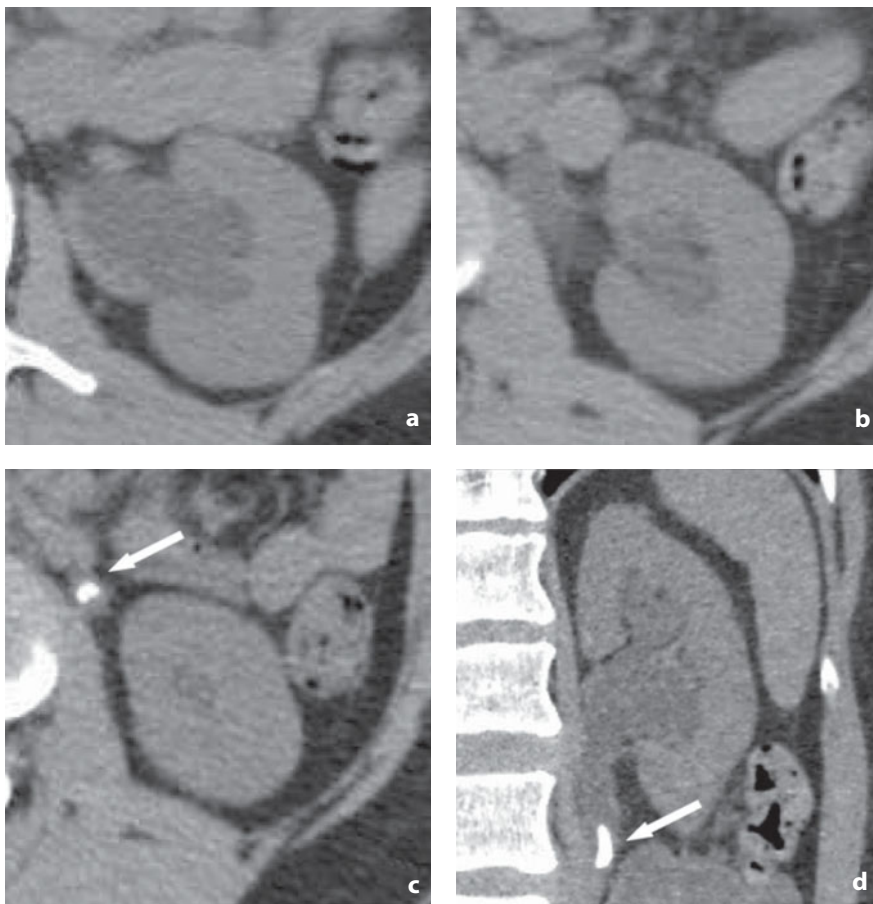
Nonenhanced CT. Ureteric stone (patient with left renal colic). Dilatation of the calices, pelvis ([a](#)), ureter with periureteric fat stranding ([b](#)) and stone (*arrow*) in the lumbar segment surrounded by ureteric wall edema (*rim sign*, [c](#)). The coronal reconstruction precisely shows the maximum dimensions and the site of the stone (*arrow*) ([d](#))
